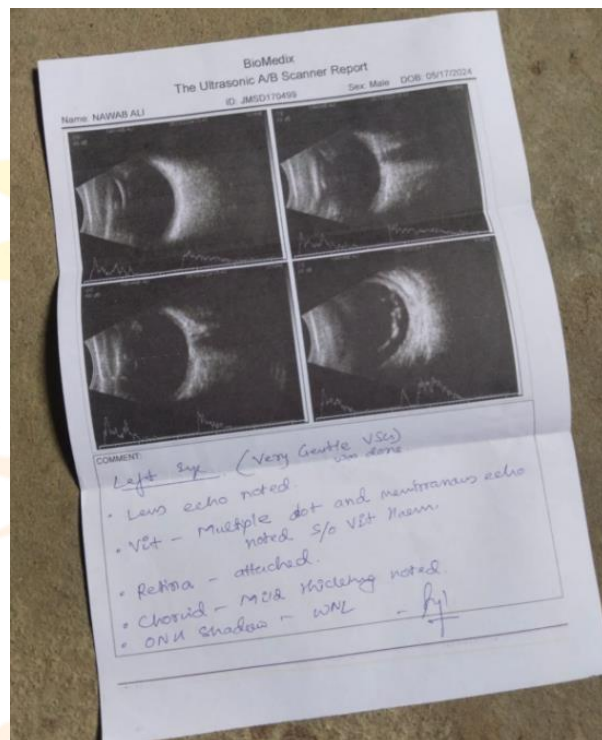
shows ultrasound b scan(very gentle) report on day 2 of trauma
